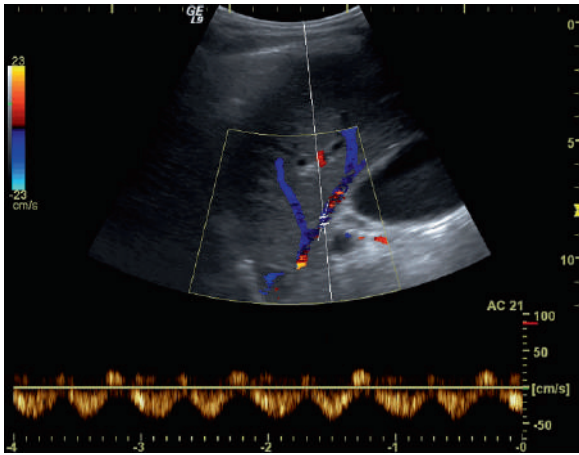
Color Doppler waveform spectrum of the hepatic veins shows the normal venous triphasic pattern
